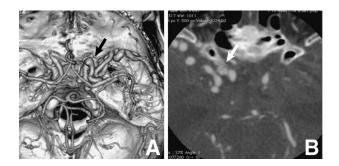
Three-dimensional computed tomography angiography shaded surface rendering image (A) and source image (B) on admission showing the dilated superficial middle cerebral vein, connecting with the dura mater at the anterior clinoid process (arrow), and two internal carotid artery aneurysms at the origin of the posterior communicating artery and the anterior choroidal artery.
